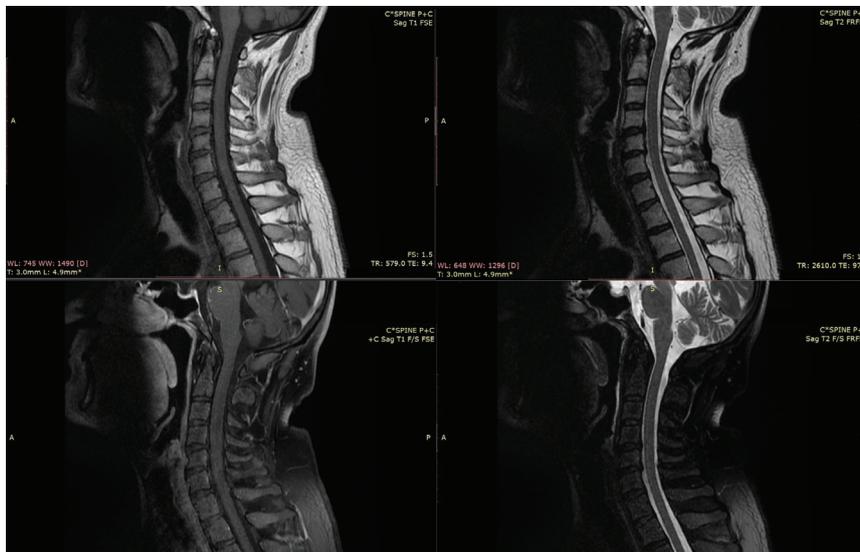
MRI of the patient's cervical spine (with contrast, showing normal findings).
